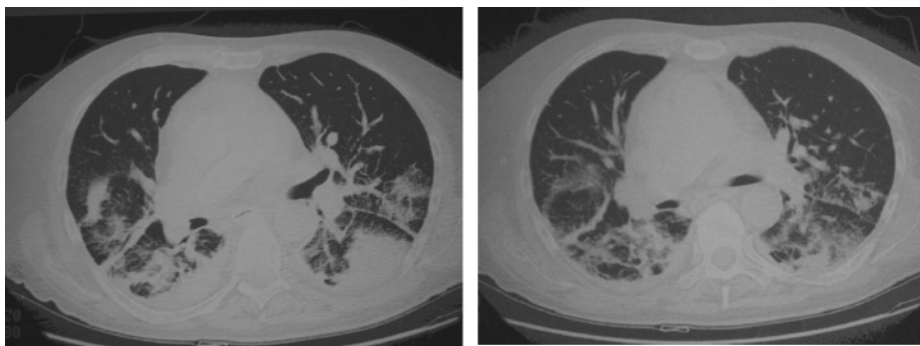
Chest computed tomography showing diffuse interstitial patchy and nodular opacities involving all the pulmonary lobes and predominantly located at the peripheral part of the lung.
